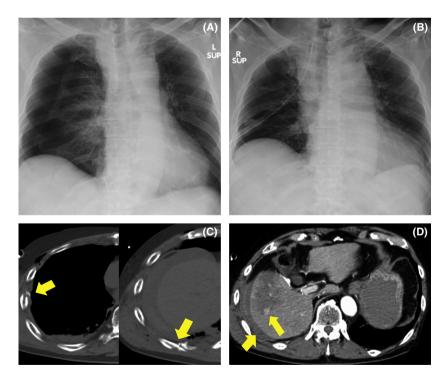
(A) Chest radiograph showing a right pneumothorax with a mediastinal shift and (B) a released pneumothorax after an intercostal tube drain is inserted. (C) Chest contrast-enhanced computed tomography (CT) scan showing right lateral and posterior displaced rib fractures and a small right hemorrhagic pleural effusion. (D) Abdominal contrast-enhanced CT scan showing a hypodense lesion in the right liver lobe with extravasation of the contrast agent and ascites around the liver.
